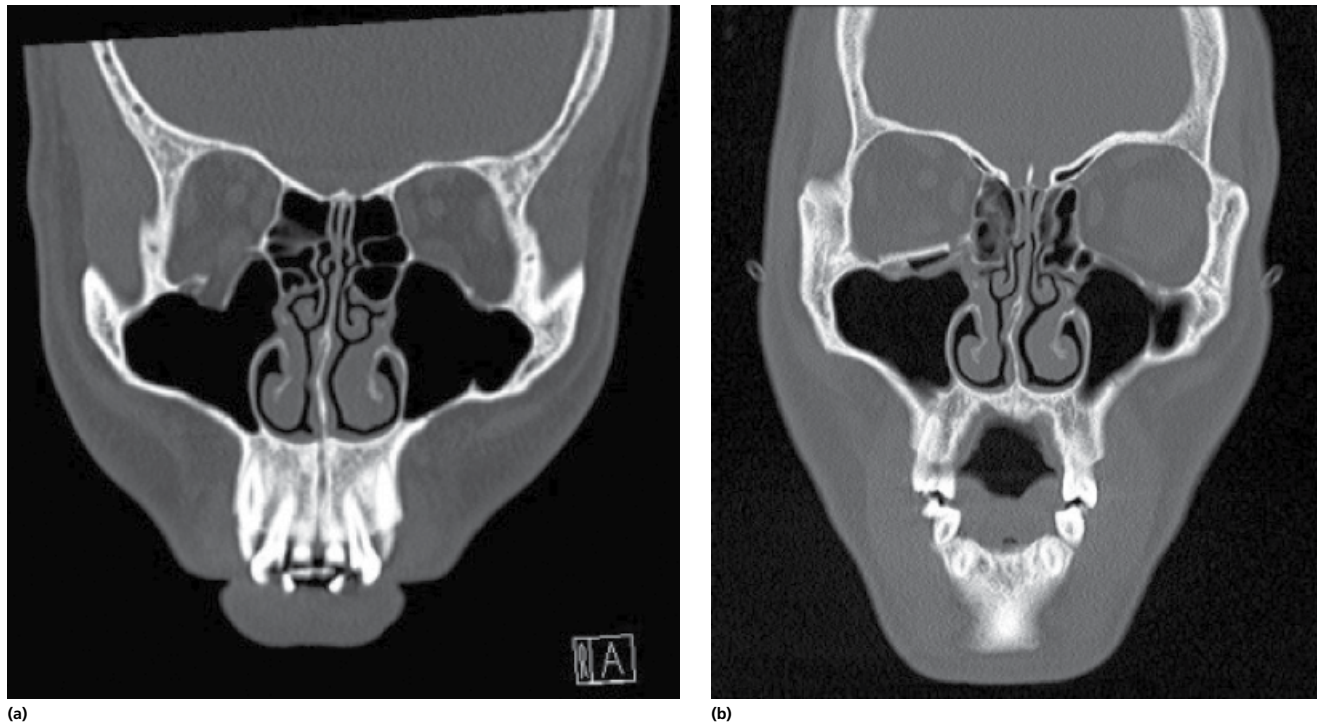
Before and after coronal CT showing the repair of a severe blow-out fracture of the orbital floor with a bone graft taken from the blade of the ilium.
